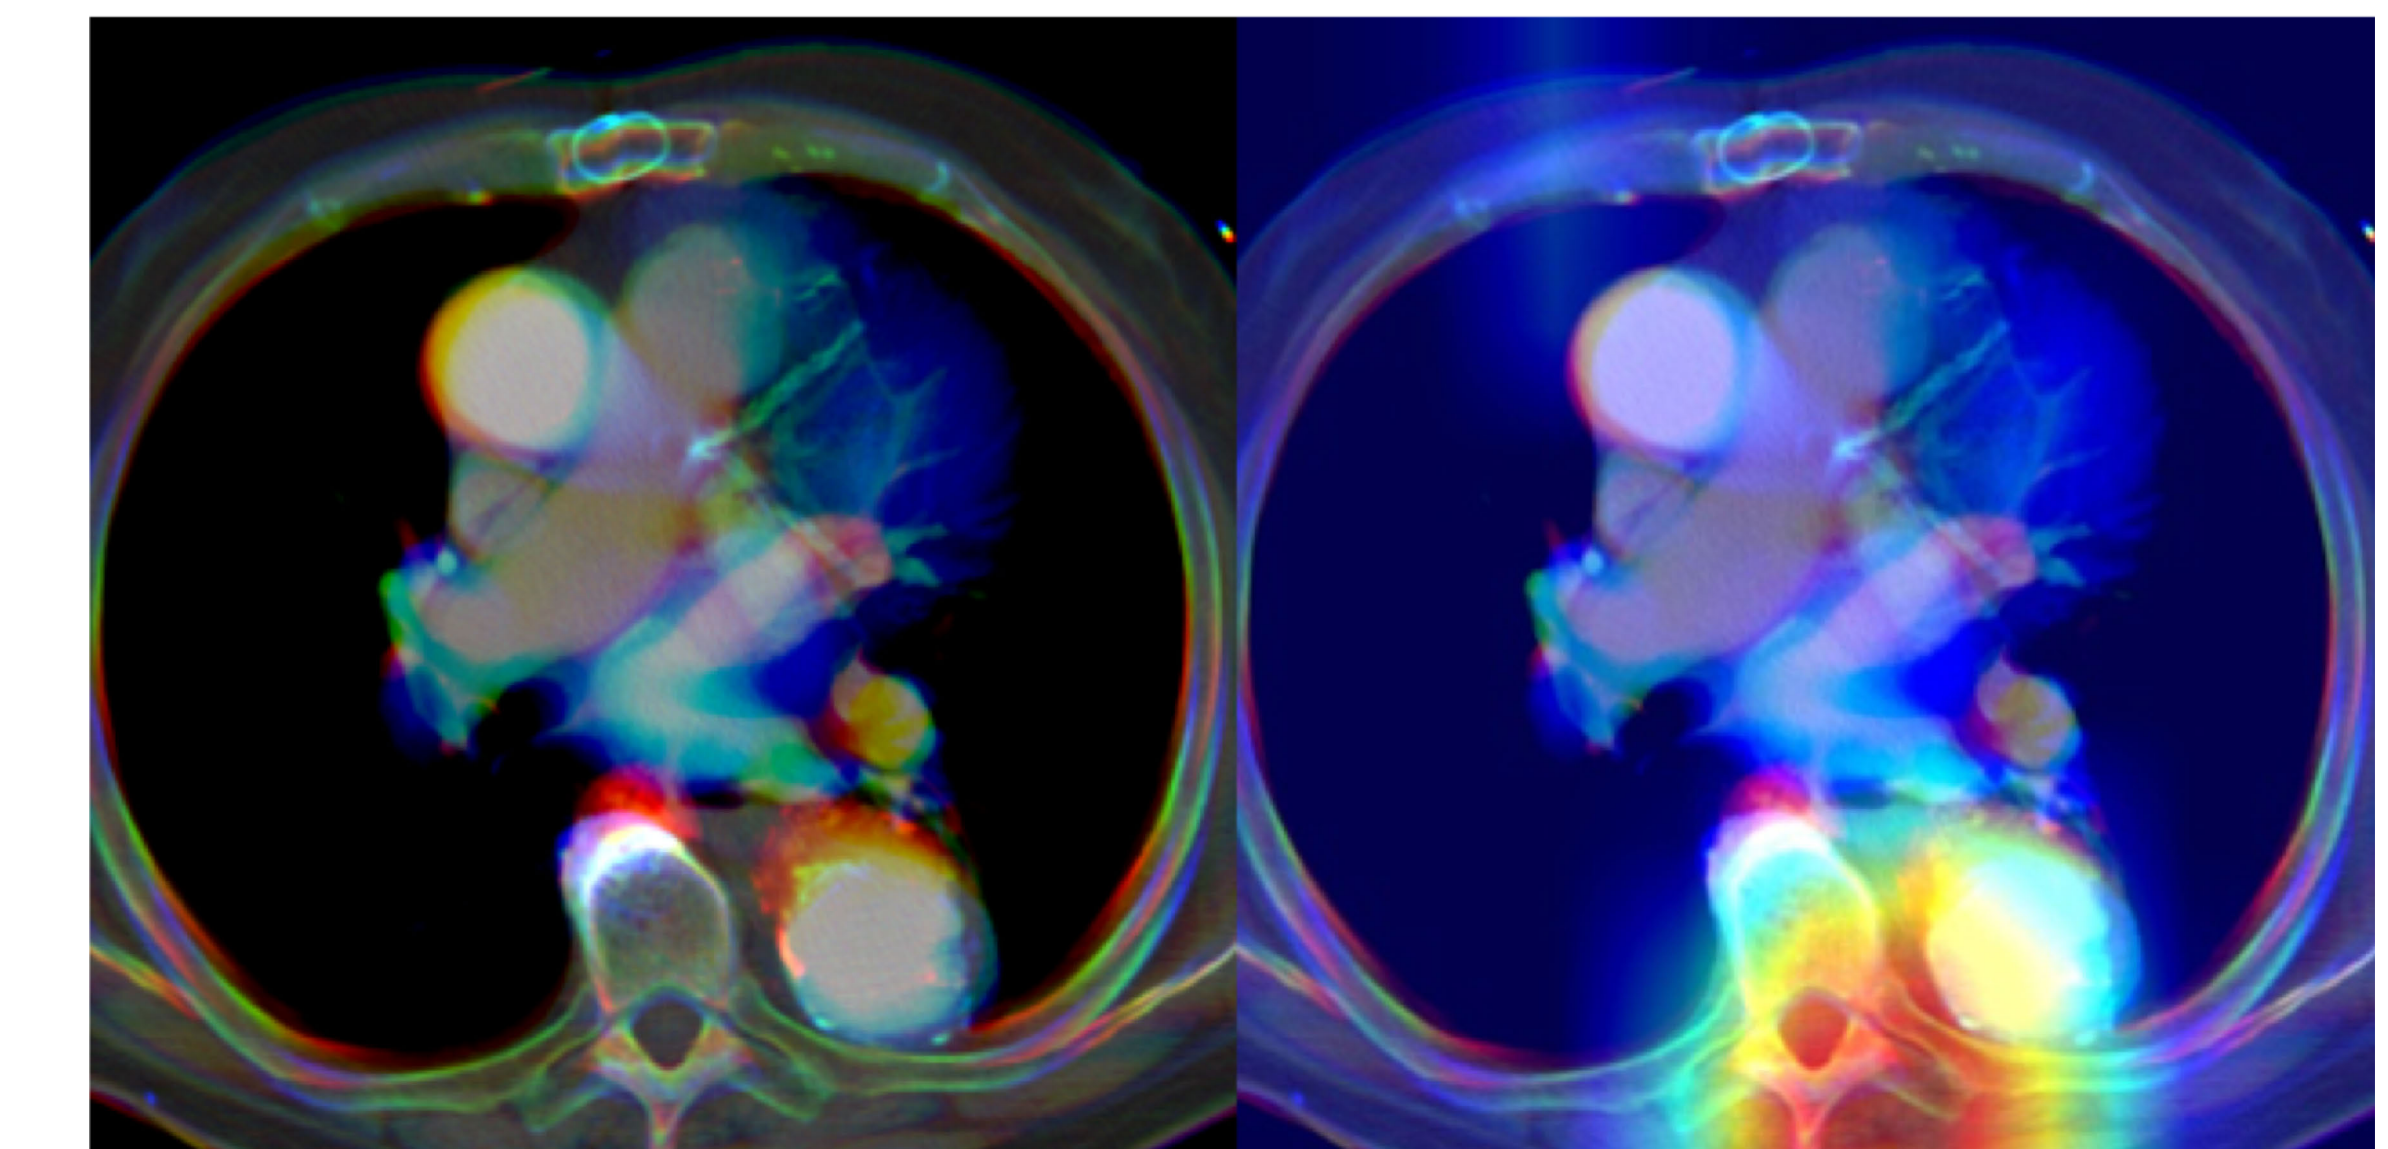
False positive: Eccentric thrombus axial CTA with colored image (left) and corresponding CAM (right)
